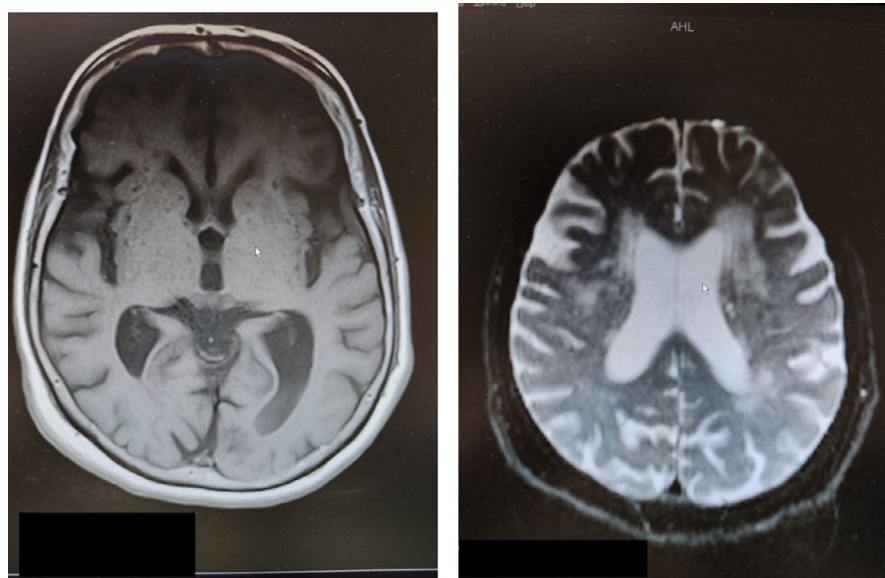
MRI showing multiple ischemic bilateral lesions due to fat embolism
